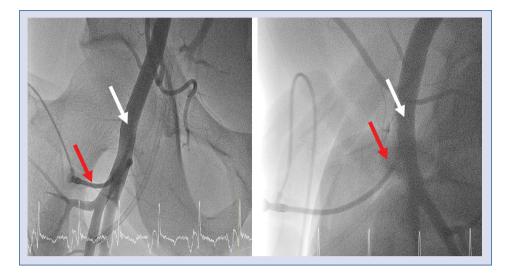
X-ray examination of patient prior to Secure arterial closure Device implantation; puncture site location control; red arrow — 6 F sheath; white arrow — common femoral artery.
